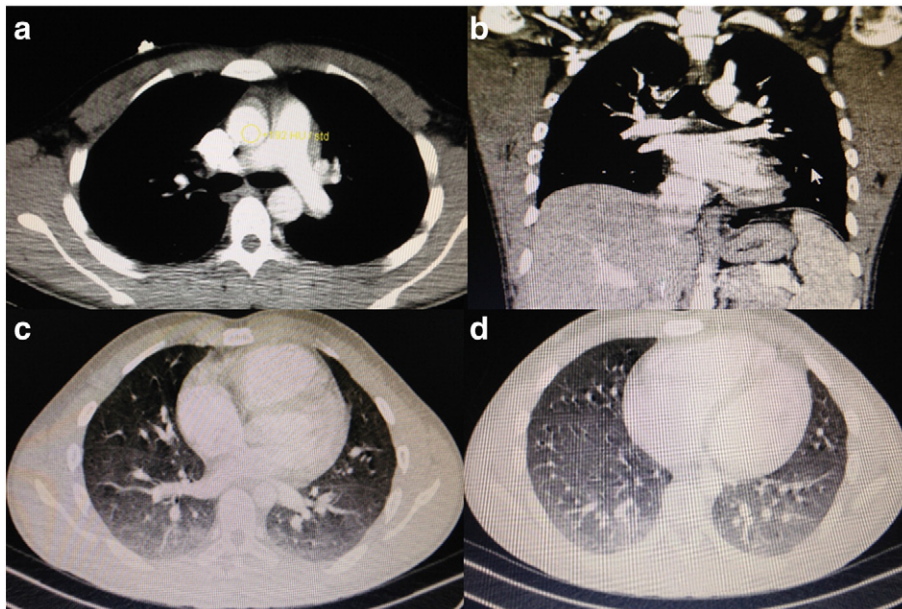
Patient's chest CT image.
